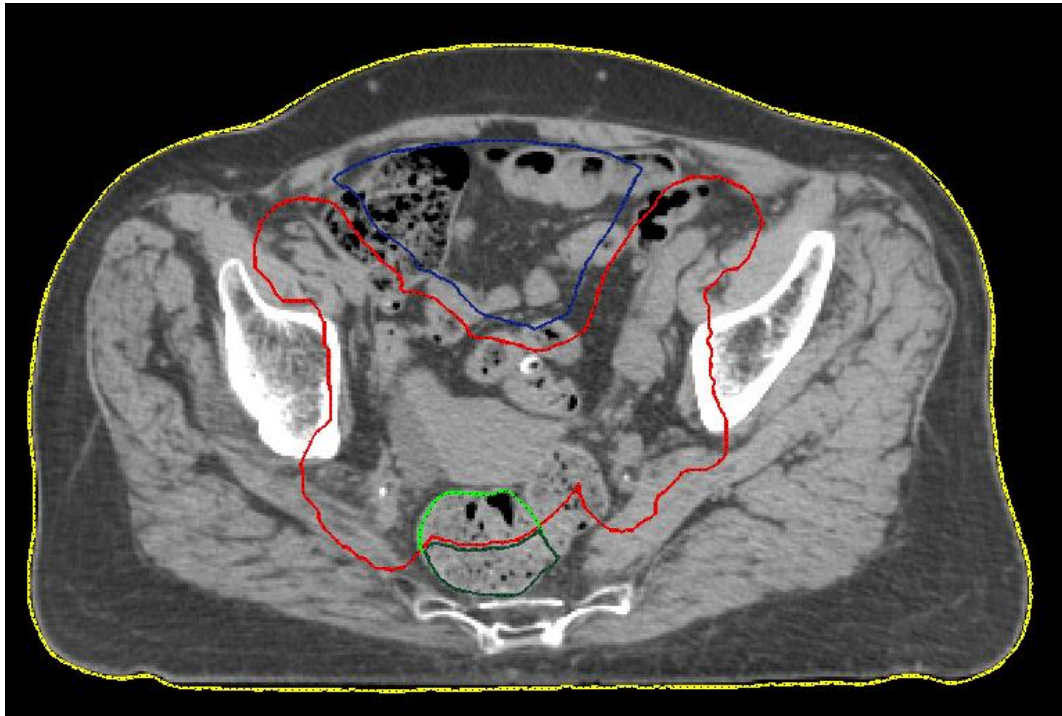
Transverse CT images with PTV (red), Rectum (light green), Body (yellow), Steering (blue) and RectumOPT (dark green) structures.
